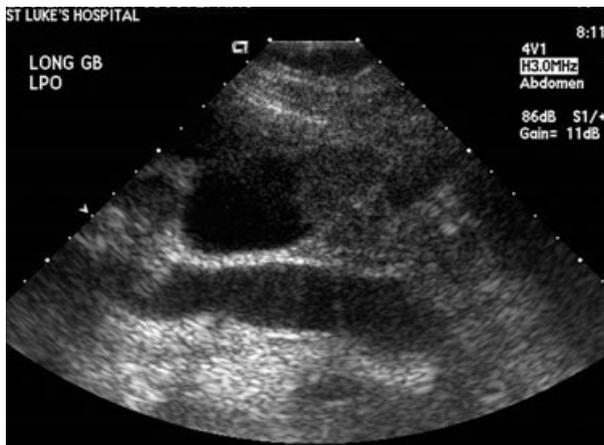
Ultrasound showing hyper-echoic lesion in the gallbladder.
